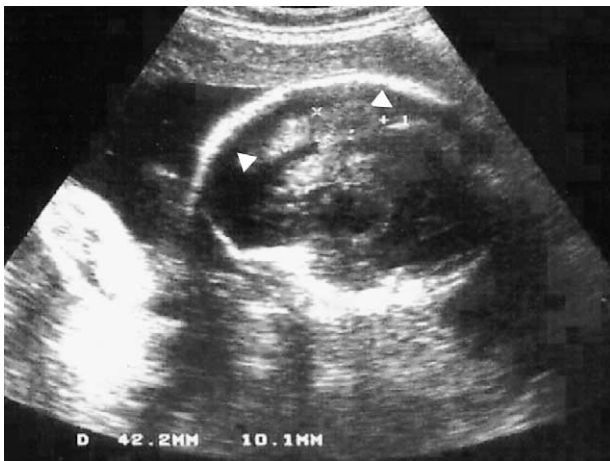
Cranial ultrasonography performed 3 days later (parasagittal section through the left cerebral hemisphere): periventricular echodensity of 42×10 mm (arrowheads), suggestive of hemorrhagic infarction.
